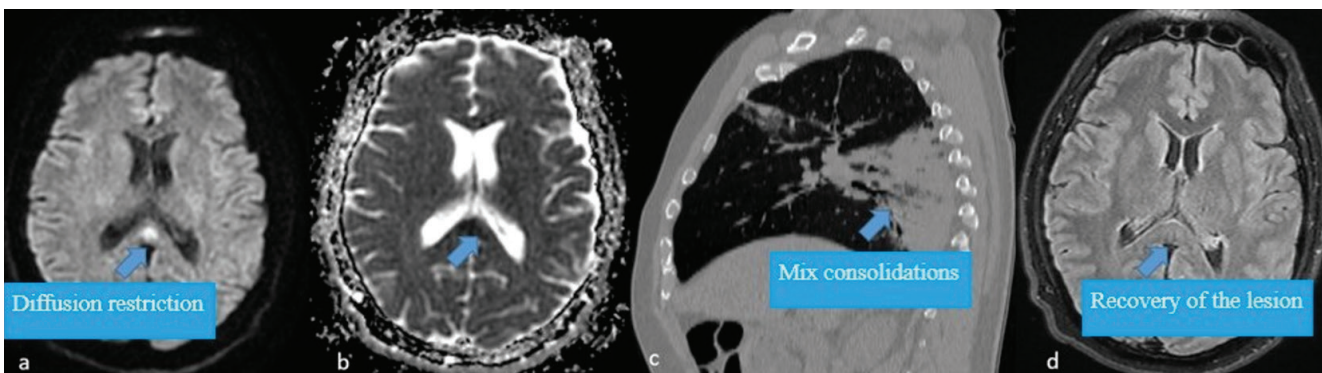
(a, b) Forty-two years old, the male patient has diffusion restriction in the middle part of splenium (c) Mix consolidations in right upper and lower lobes with bronchograms in the sagittal reconstruction of thorax computed tomography mediastinal window (d) Recovery of the lesion in axial FLAIR sequence without any sequelae or signal 1 month (arrows)
